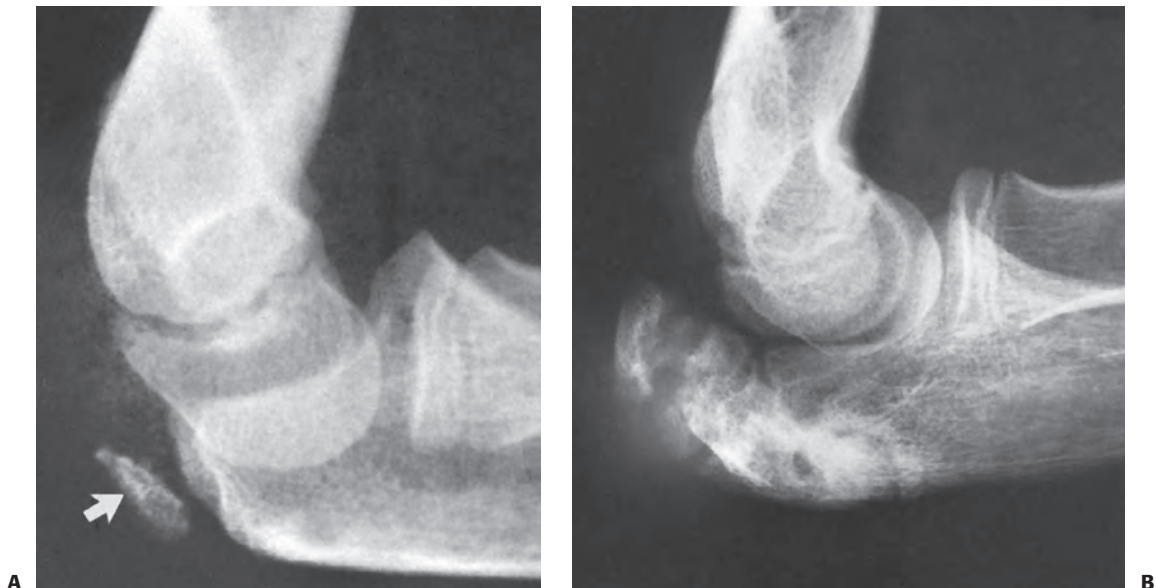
A: Injury film showing partial avulsion of the tip of the olecranon apophysis (*arrow*). B: Radiograph taken 4 years later shows a marked elongation and irregular ossification of the apophysis. (Courtesy of Joel Goldman, MD.)
